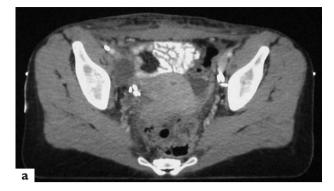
Computed tomography (CT) scan (a) and radiography (b) after hysterectomy and colpectomy in a case of primary carcinoma (same patient as in Figure 32.1)
